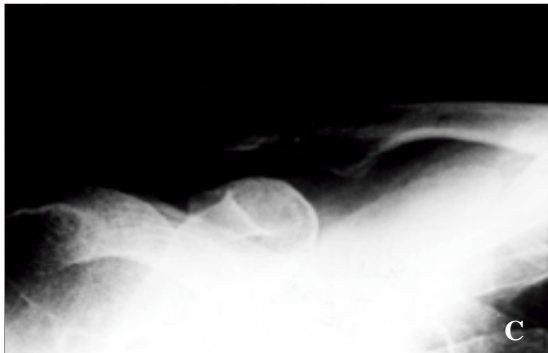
Anteroposterior radiograph of the right clavicle of a 52-year-old woman. The fracture showed long oblique pattern and osteoporosis
